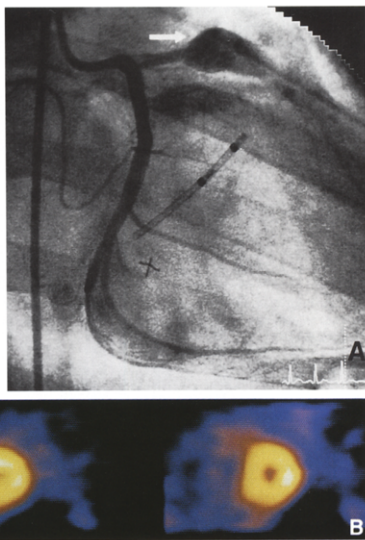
Patient 5. A, Coronary angiogram, right anterior oblique projection. A small-caliber aneurysm (arrow) is evident in the left anterior descending coronary artery. B, Stress (upper images) and rest (lower images) single-photon computed tomographic (SPECT) sestamibi images in the short-axis view. A stress-induced perfusion defect in the anterior wall (arrows) is evident. The rest images are normal.
